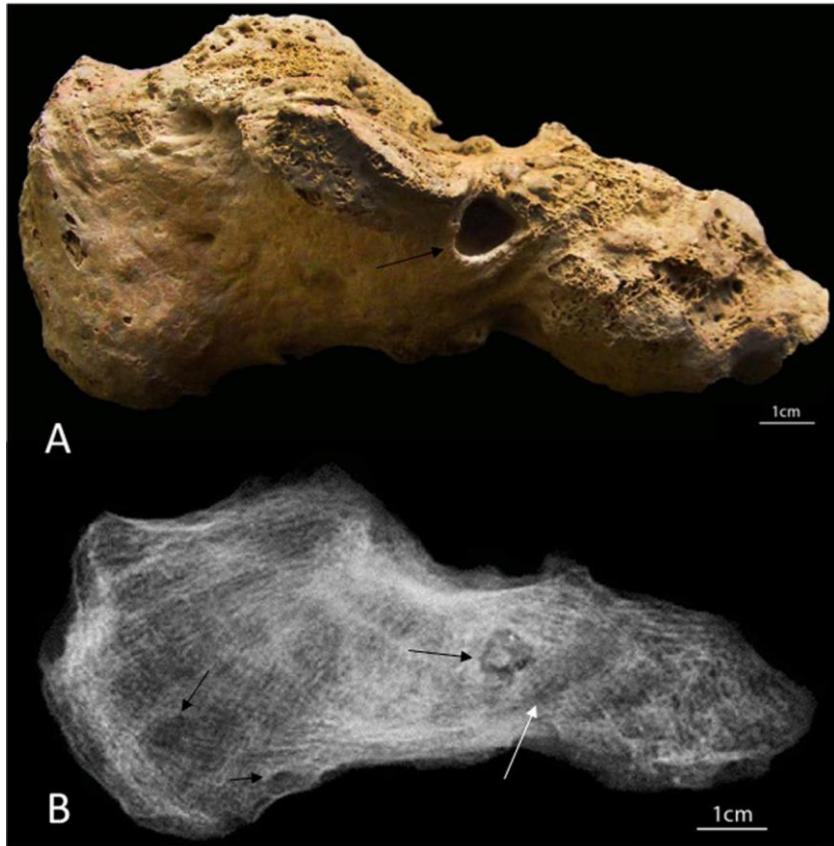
Ankylosis of the left calcaneous and cuboid (3D imaging available at <https://sketchfab.com/models/7338e70695b34439b8421d014b593610>). (A) Photography showing external foci (blackarrow). (B) Radiograph showing multiple foci (black arrows) and the lines (white arrow) between the calcaneus and cuboid.
